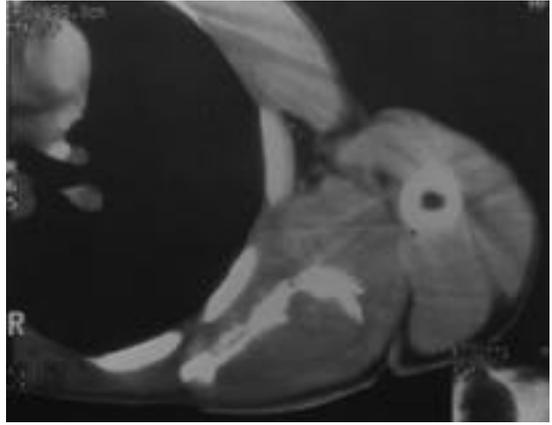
CT shows cortical destruction at the anterior and posterior margins, and prominent bony trabecular formation at the lateral border. The lesion shows prominent soft tissue mass at the posterior aspect of the scapula with sharp margin.
